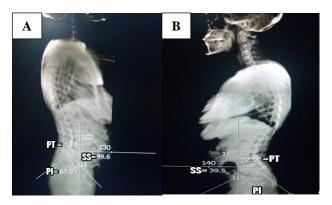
Pre and postoperative radiographic measurement of PI (pelvic incidence), SS (sacral slope), PT (pelvic tilt).
